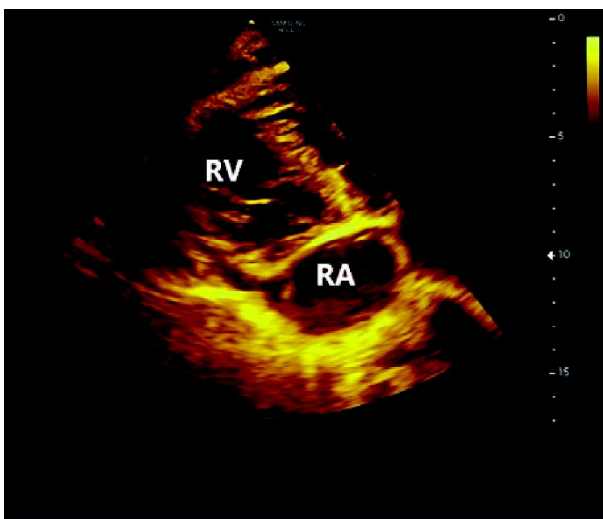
Echocardiography showing noncompacted RV.
